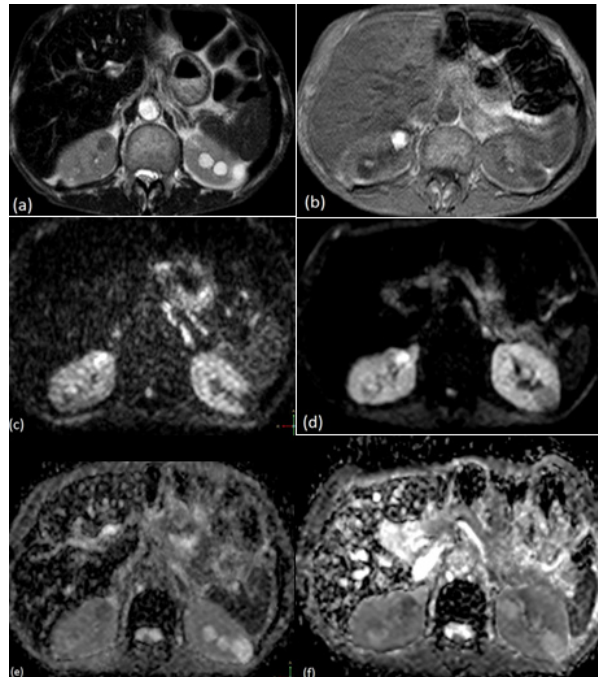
a-e). Hemorrhagic cyst in the right kidney and simple cysts in the left kidney in a 69-year-old male patient. On T2w images, one hypointense lesion in the right kidney and a few hyperintense lesions in the left kidney are shown (a); On T1w images, the lesion on the right is hyperintense, and the lesions on the left are hypointense (b); While restricted diffusion was observed in the right lesion, it was not observed in the left lesions on DWI (c-f); The ADC value of the right lesion was measured as $1.57 \times 10^{-3} \text{ mm}^2/\text{s}$ at $b=1000$ (e) and $1.58 \times 10^{-3} \text{ mm}^2/\text{s}$ at $b=500$ (f). The ADC value of the largest left lesion was measured as $3.09 \times 10^{-3} \text{ mm}^2/\text{s}$ at $b=1000$ (e) and $3.50 \times 10^{-3} \text{ mm}^2/\text{s}$ at $b=500$ (f)
